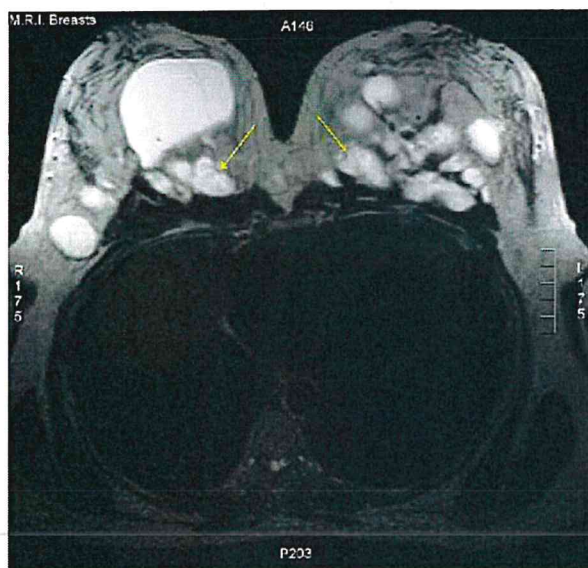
Axial non contrast T2 weighted MR image demonstrate multiple cystic image within the breast tissue and pectoral muscles.
